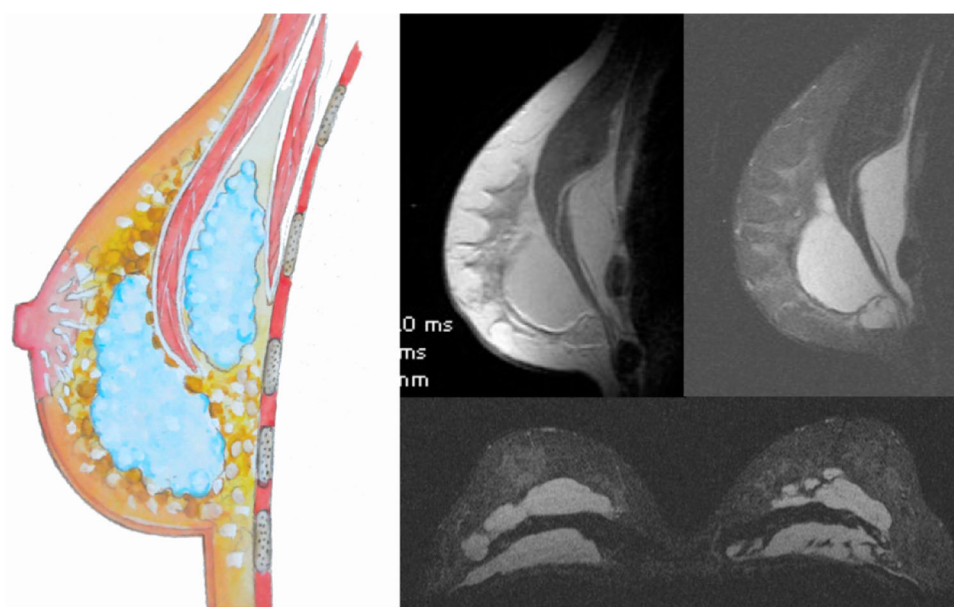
A 56-year-old woman with 20-year-old 200 cc ruptured silicone implants, (left) rejected new implants and received HA filling of the old implant pocket (150 cc of Macrolane) long duration confirmed with MRI 5 years after implant removal
